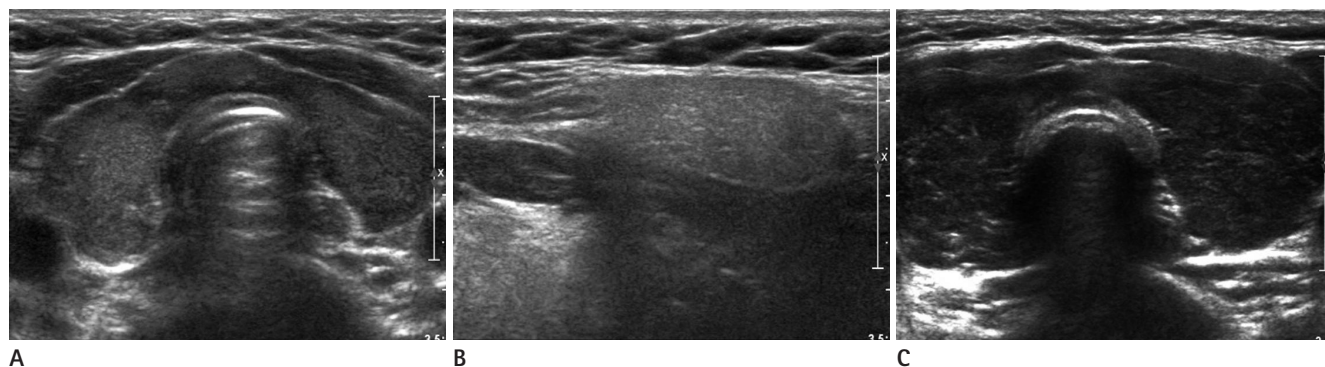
Ultrasound (US) of group A and group B.
